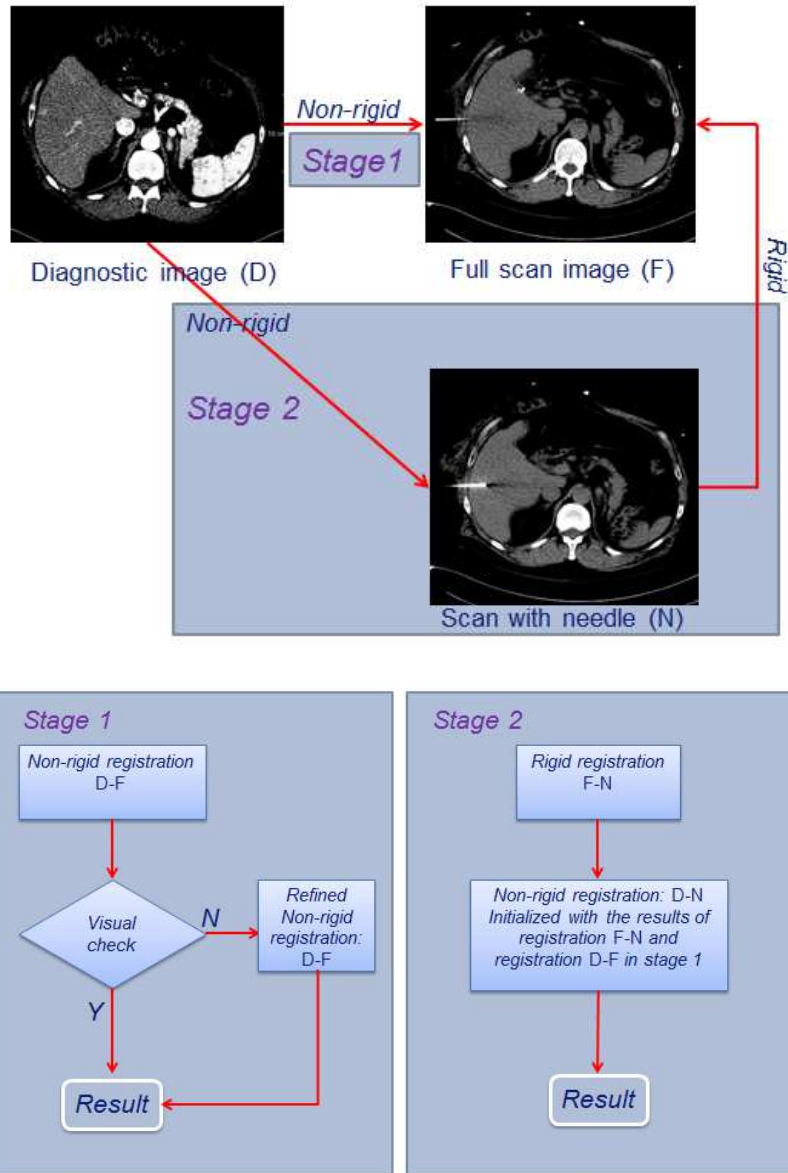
Registration scheme of the diagnostic contrast enhanced CT image D and the intra-operative CT images: stage 1 is registration between the image D and the full operative image F; and stage 2 is the registration between the image D and the operative image N.
